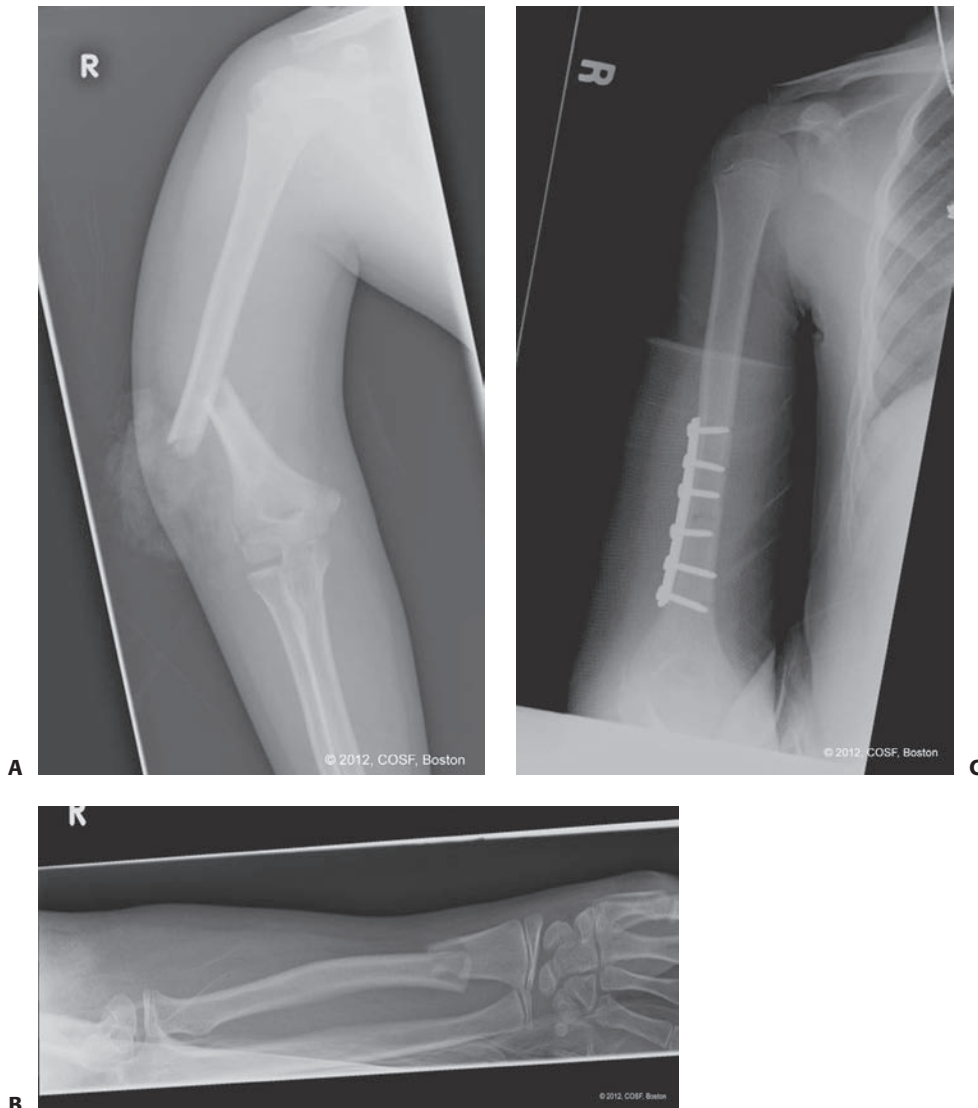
Floating elbow injury. A: AP radiograph depicting an open humeral diaphyseal fracture in a 10-year-old female. B: An ipsilateral radius fracture is also seen, consistent with a floating elbow injury. C: Postoperative radiograph after open irrigation and plate fixation of the humeral fracture. The radius fracture was also stabilized with internal fixation.
